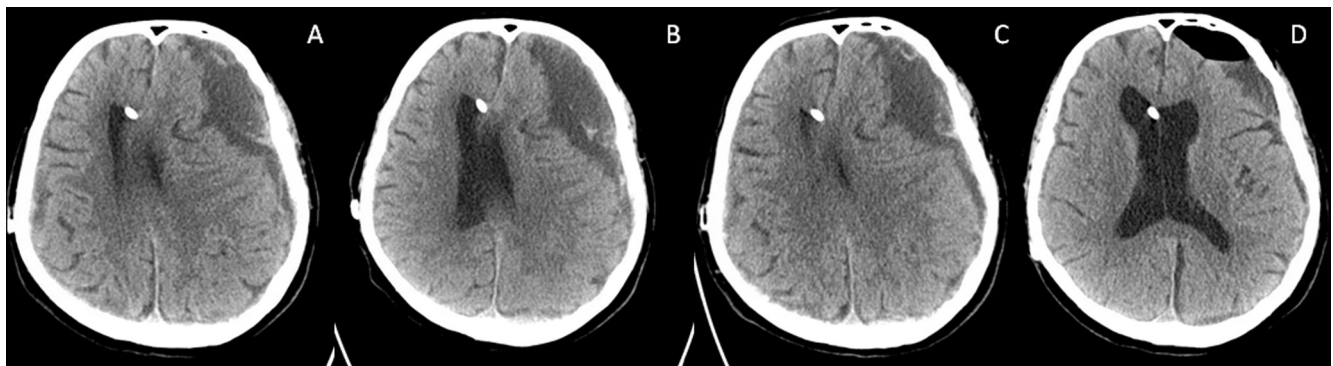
Axial non-contrast CT scan of the head demonstrating left sided acute on chronic subdural hematoma, with significant mass effect and midline shift (A). Also seen is the ventricular end of the shunt from prior surgery. Repeat axial CT scan performed at 6 hours (B) and 24 hours (C) showing no increase in the size of the hematoma. Post-operative axial CT scan of the head (D) demonstrating good decompression with improvement in mass effect and midline shift and no hemorrhagic complication.
